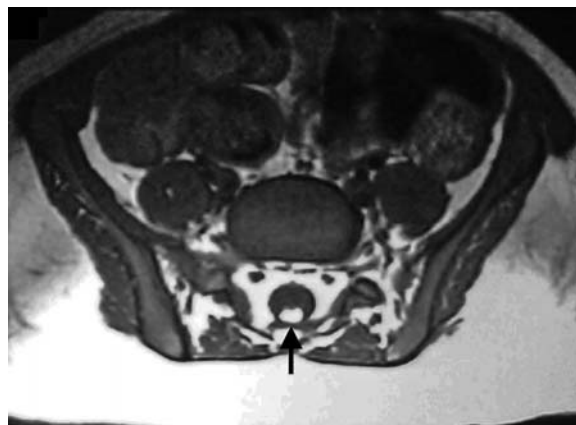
Axial T1-weighted MR image of a 2-year-old girl shows a tethered cord with a lipoma (arrow)
